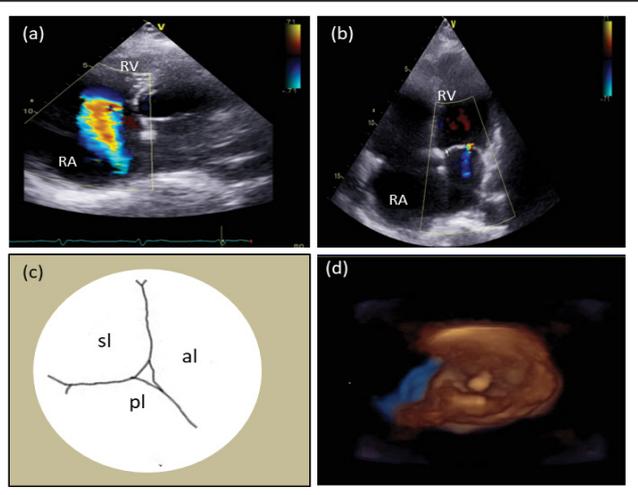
2D Echocardiographic (colour Doppler) assessment of tricuspid valve (a): showing moderate tricuspid regurgitation; (b): Trivial mitral regurgitation; (c): Normal tricuspid valve (En-face view); and (d): 3D Echocardiographic view shows a tethered posterior tricuspid leaflet (RA: right atrium; RV: right ventricle, pl: posterior leaflet, al: anterior leaflet, sl: septal leaflet).
